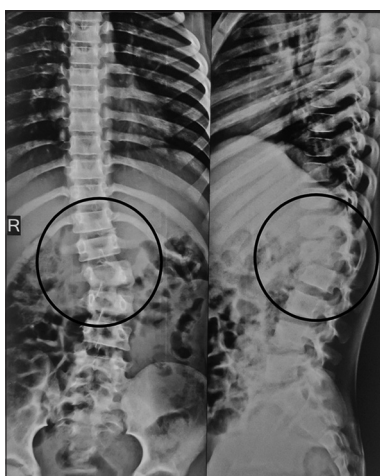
X-ray anteroposterior and lateral views showing kyphosis and traumatic spondylolisthesis
